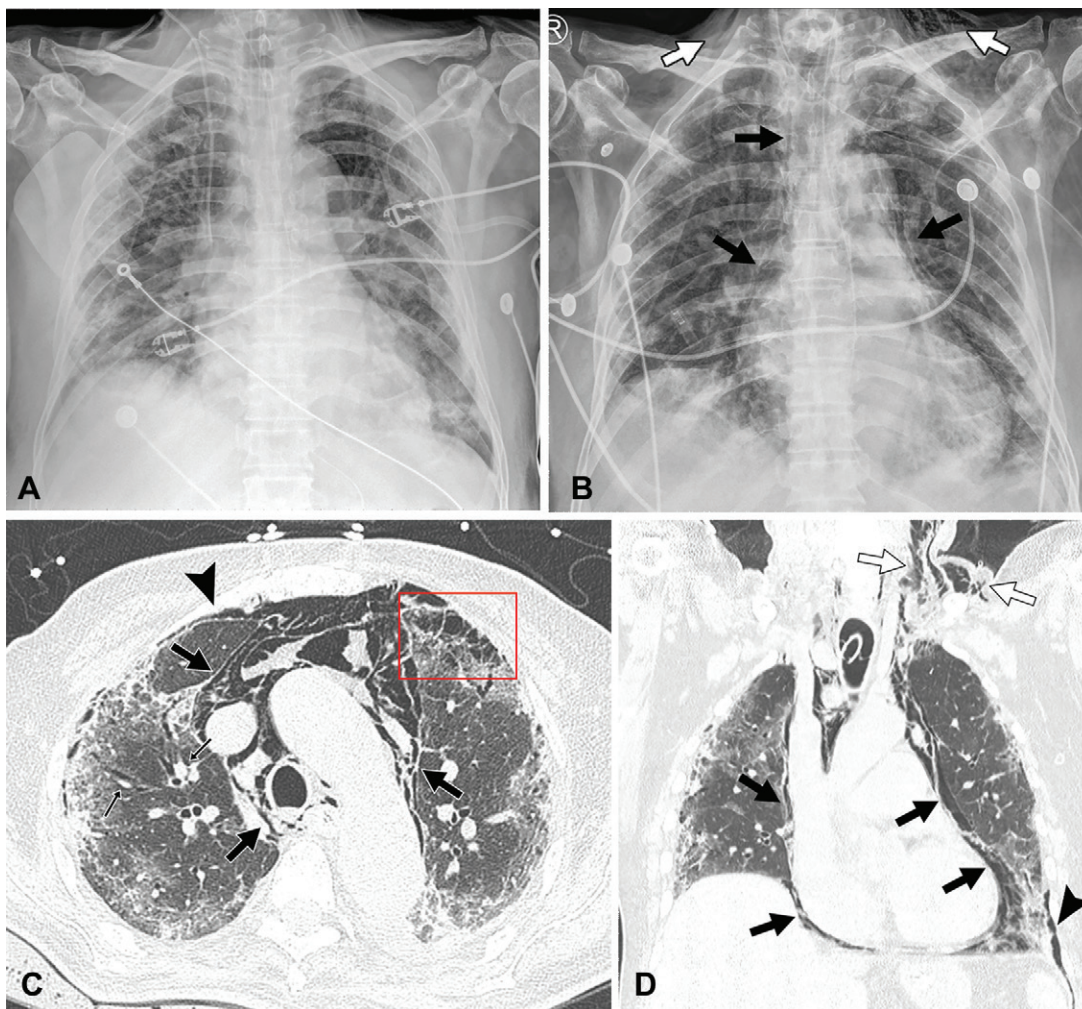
Images of COVID-19 pneumonia with oxygen toxicity and barotrauma at the time of Delta variant–dominant period in a 71-year-old unvaccinated man with diabetes. (A) Chest radiograph obtained 10 days after positive nucleic acid amplification test for COVID-19 shows extensive parenchymal opacity involving bilateral lungs. He was transferred to the intensive care unit due to worsening of hypoxemia and was given mechanical ventilation with prolonged oxygen supply. (B) Follow-up chest radiograph obtained 25 days after initial diagnosis of COVID-19 demonstrates identifiable pneumomediastinum (black arrows) and subcutaneous emphysema (white arrows) with parenchymal opacities. (C) Transverse and (D) coronal reformatted images of nonenhanced CT scans depict mixed ground-glass opacity, consolidation, and reticulation in the peripheral areas of both lungs associated with interstitial emphysema (small arrows in C) causing Macklin effect, pneumothorax (arrowhead), pneumomediastinum (black arrows) and subcutaneous emphysema (white arrows in D). Note air cysts in the anterior left lung (box in C). One month after receiving mechanical ventilation with corticosteroid treatment, the patient recovered and was discharged.
